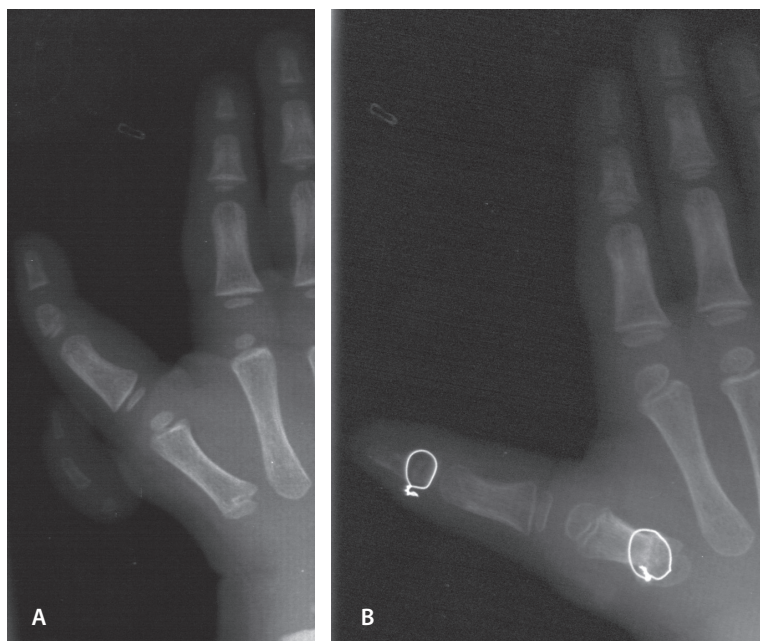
A; Preoperative radiographs of a patient with trapezoid type triphalangeal thumb and radial polydactyly. B; Postoperative radiographs after correction of the triphalangeal thumb by removal of the distal interphalangeal joint and extra phalanx and fixing the proximal interphalangeal joint to the distal phalanx (Peimer 1985). To reduce additional length of the first metacarpal a reduction arthrodesis of the first metacarpal has been done. The additional hypoplastic radial ray was removed in the same session.
